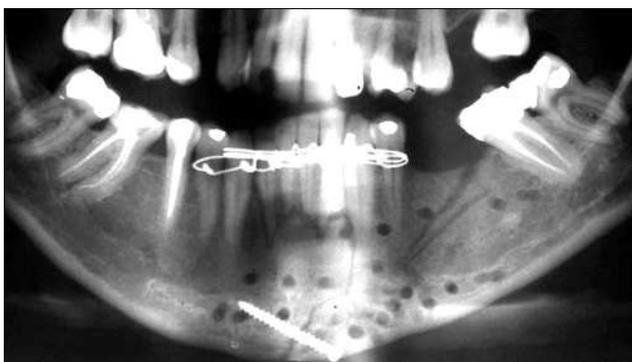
Panoramic radiography from the seventh day of the postoperative period
